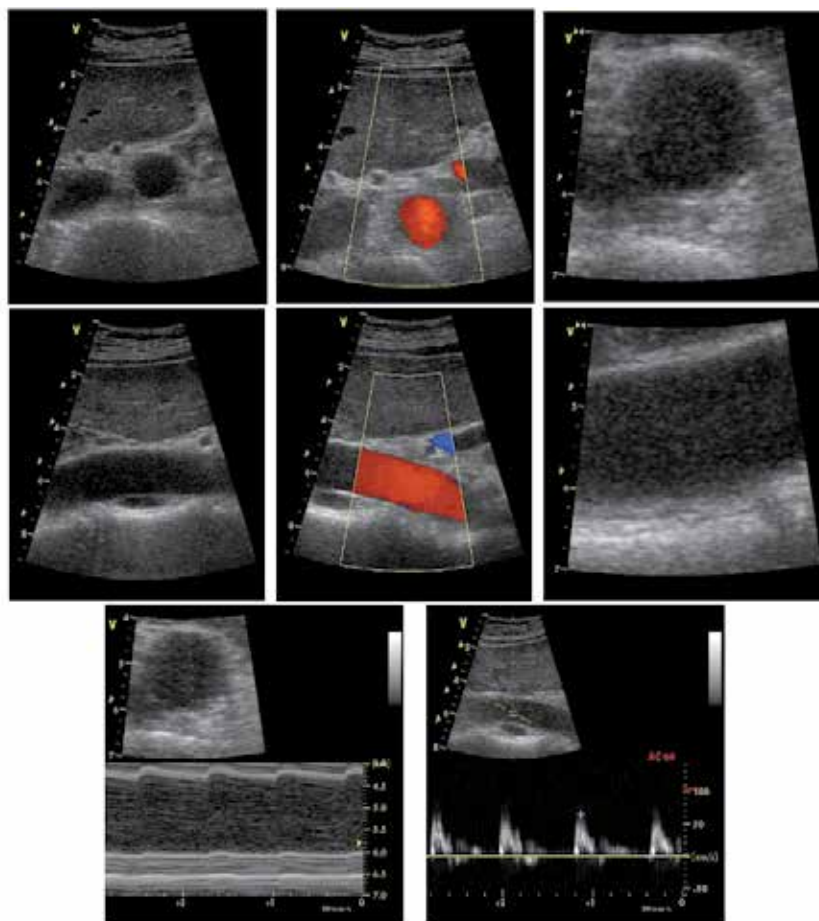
Ultrasound images of abdominal aorta. Upper row: Cross-sectional view, 2D B-mode, colour Doppler (duplex) and zoomed B-mode image, respectively. Mid row: Same as upper row, but with longitudinal view. Lower row: M-mode (left) and Doppler velocity spectrum.
